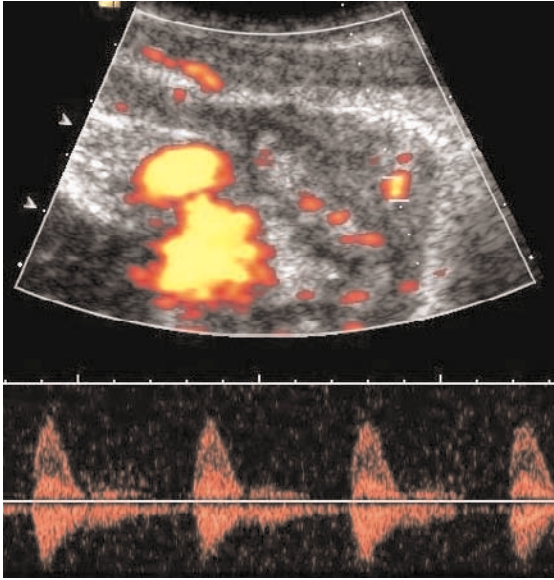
Color Doppler ultrasound: increased vascularity of the thickened bowel wall
